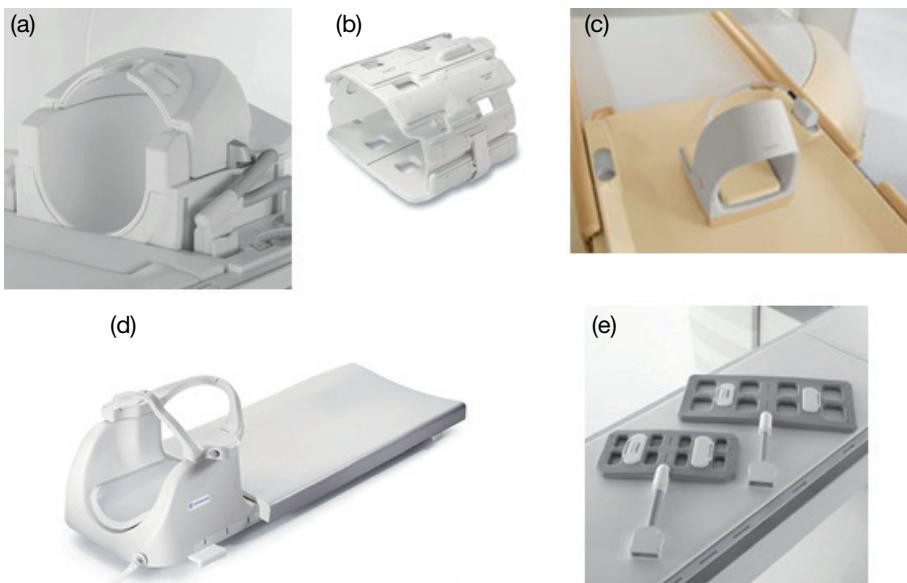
MRI receiver coils: (a) Siemens 32 channel head coil; (b) General Electric torso array coil; (c) Philips Neck coil; (d) General Electric cervical, thoracic, lumbar spine coil; (e) Siemens four channel flex coils.
